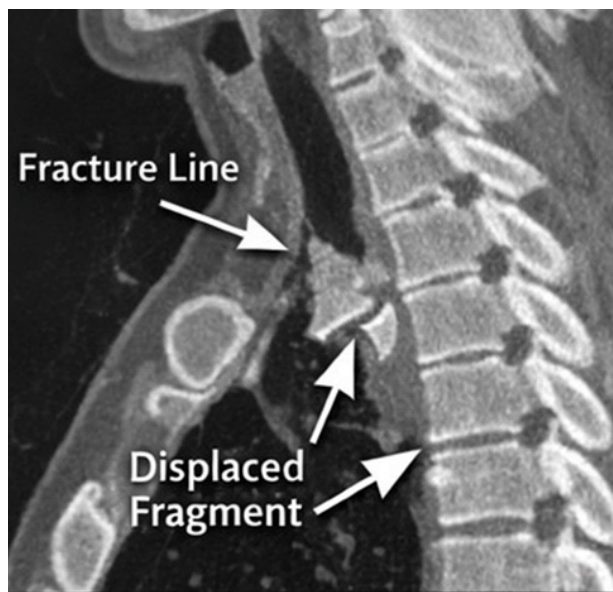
Sagittal reconstructed CT image demonstrating a displaced sternal fracture with posterior displacement of fracture fragments, clearly delineating fracture morphology.
